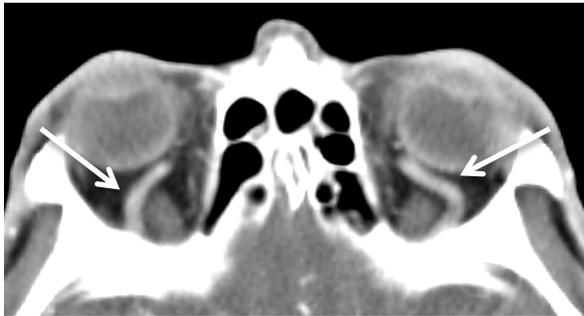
Prominent dilated ophthalmic veins (white arrows) (55-year-old male). Posttraumatic carotid cavernous fistula of the left cavernous was documented. CT, axial section.
